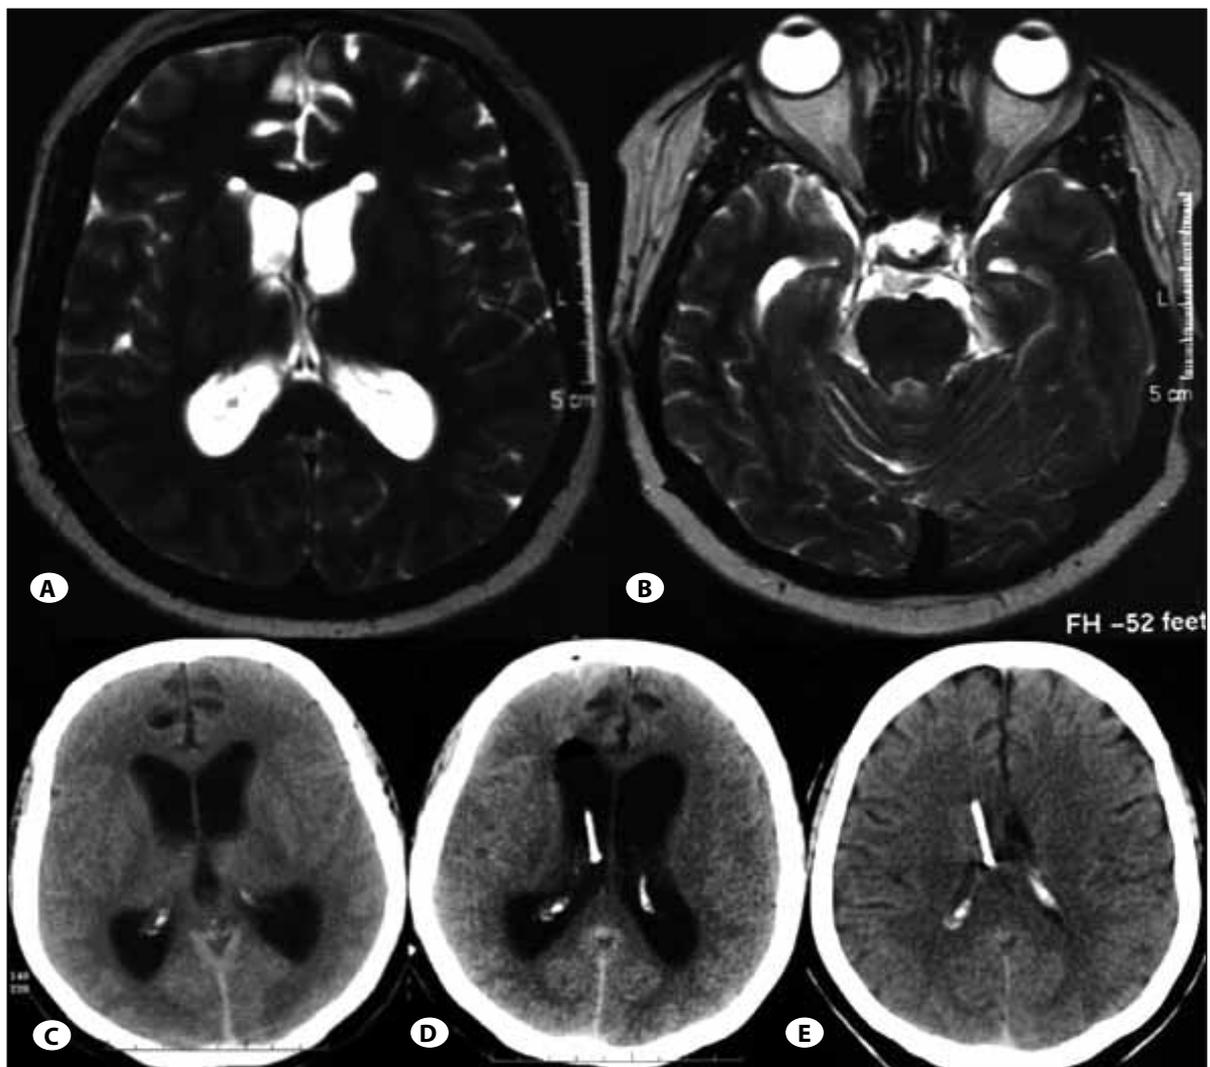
The T2-weighted MR image excluded hydrocephalus on the first admission (A-B). During her hospitalization, the ventricles began to dilate (C) and eventually a VP shunt system was inserted (D). The patient was admitted for her increased ICP symptoms several weeks after her first discharge (E).
